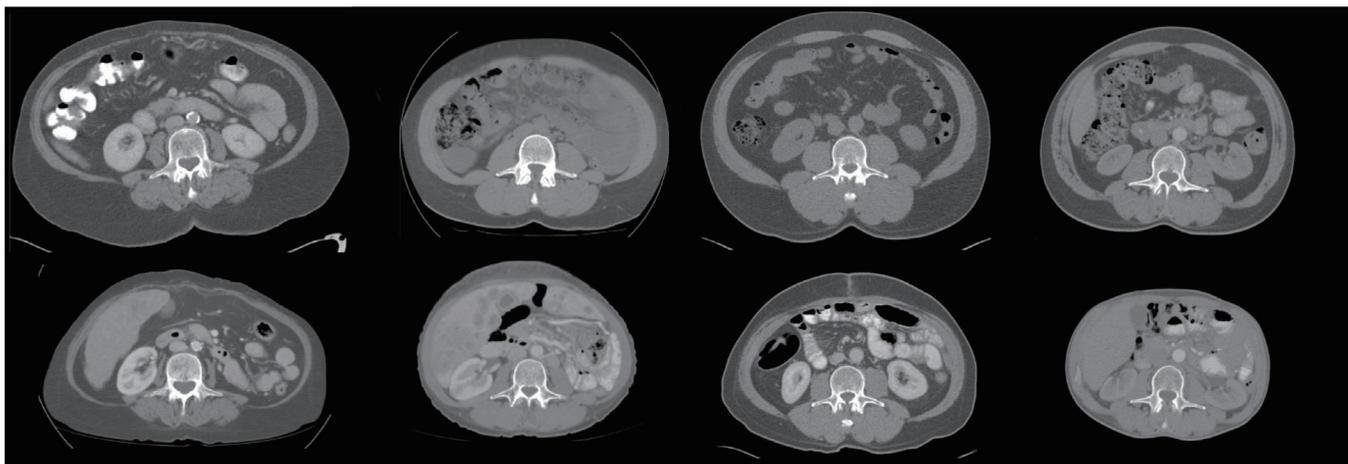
Computed tomography images framing the year of death in four different patients. Axial abdominal images at the 3rd lumbar vertebra. Upper row: 4 unique patients with advanced cancer, initial computed tomography (CT) scan taken in the 1st month of the year of death. Lower row: last CT scan of record in the same 4 patients, taken within the month of death.
